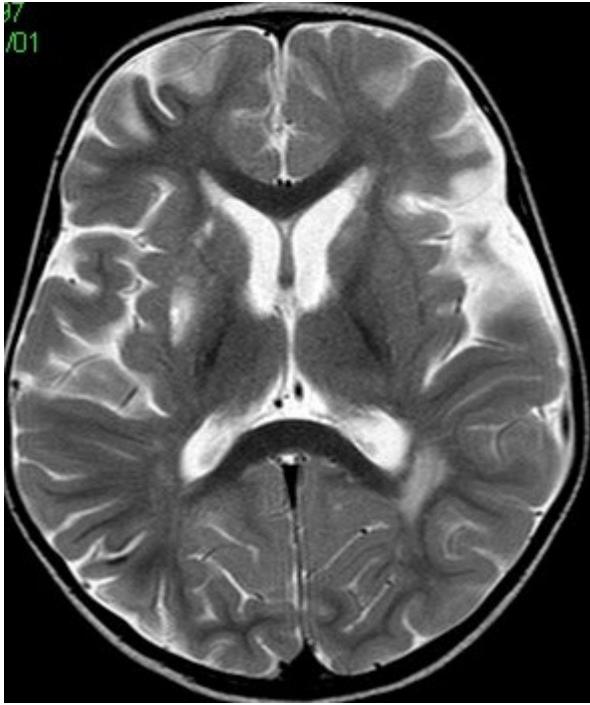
MRI and MRA of patient with moyamoya and Down's Syndrome
